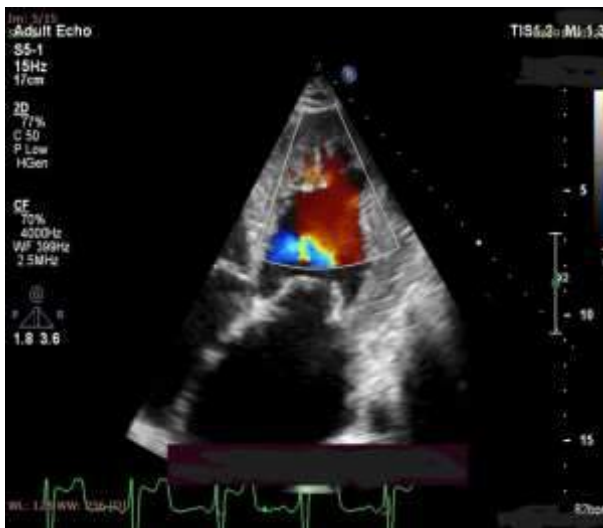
colour doppler flow within the deep intertrabecular recesses
